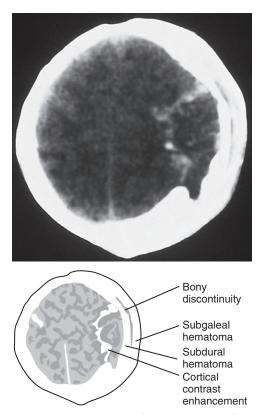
Cerebral contusion. CT scan from a 4-week-old infant who allegedly rolled out of his crib while the side rails were up shows a large subgaleal hematoma obscuring an underlying fracture, severe cerebral swelling with a shift of the midline, and cortical contrast enhancement indicative of a cerebral contusion. (*Courtesy Division of Neuroradiology, University Health Center of Pittsburgh, Pittsburgh, Pa.*)
